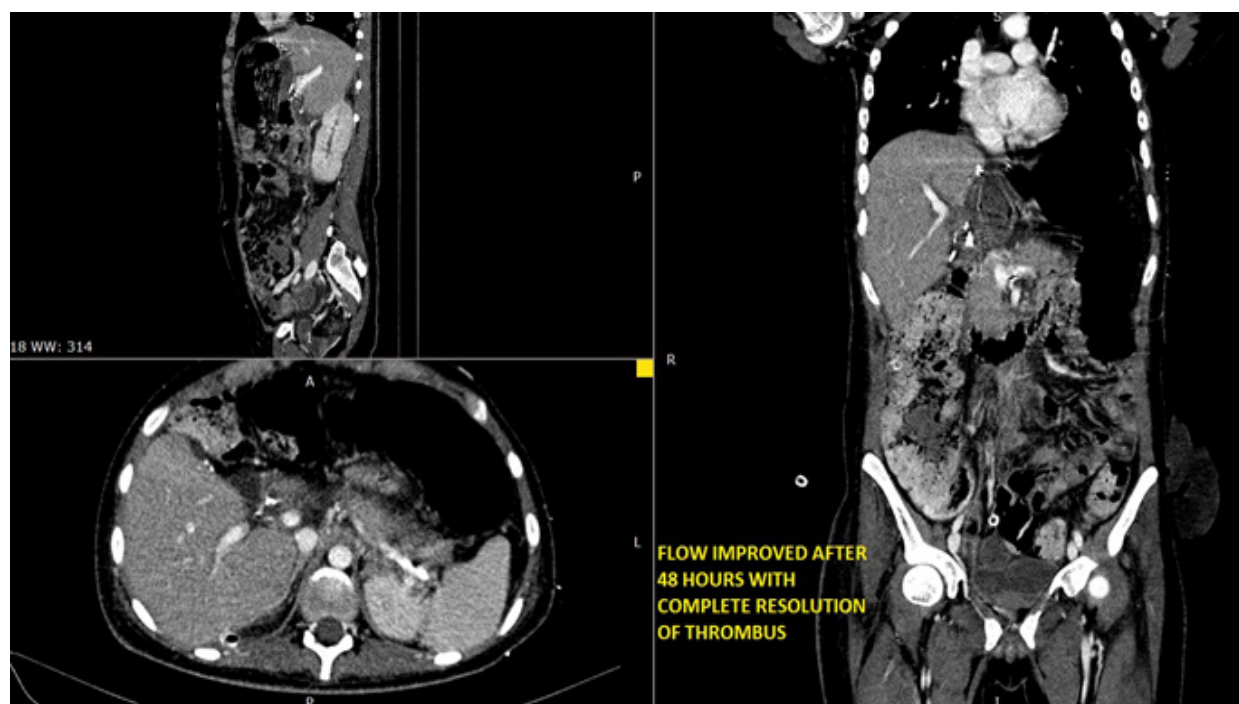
CT scan after 48 hours (post-thrombolytic therapy) showing complete resolution of thrombosis.
